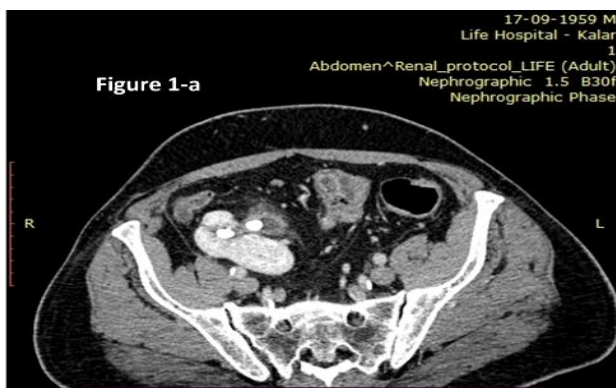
(a, b, c): Computed tomography (CT) revealed Right pelvic malrotated kidney with 2 obstructing stones and moderate dilatation of renal pelvis with marked thickness of urothelium (chronic infection)
